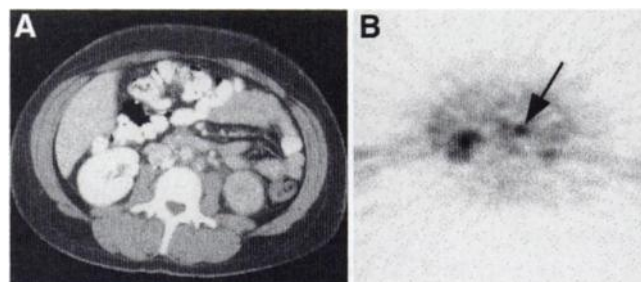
Contrast-enhanced CT image (A) and FDG PET image (B) of 37-y-old woman with cervical cancer and lymph node metastasis (patient 8). Although CT shows equivocal-sized (1 cm in diameter) para-aortic lymphadenopathy, PET image clearly shows intense focal FDG accumulation in lymph node (arrow). Metastasis was confirmed by follow-up CT.
